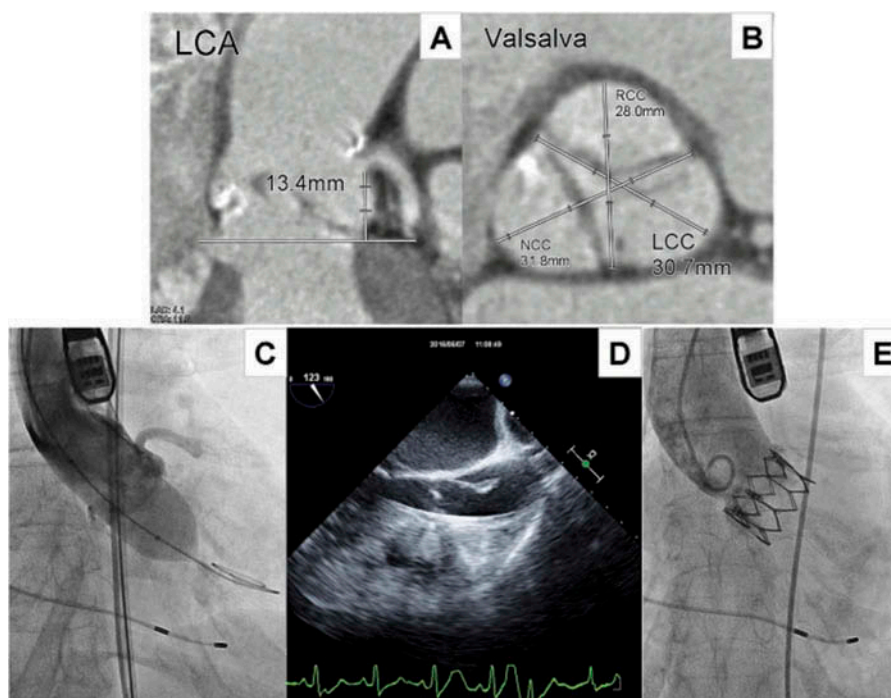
A: Left main coronary artery height; B: Sinus of valsalva dimension; C: Aortography during valvuloplasty; D: Transesophageal echocardiography after the valvuloplasty; E: Aortography after Sapien XT (26mm) valve implantation.
